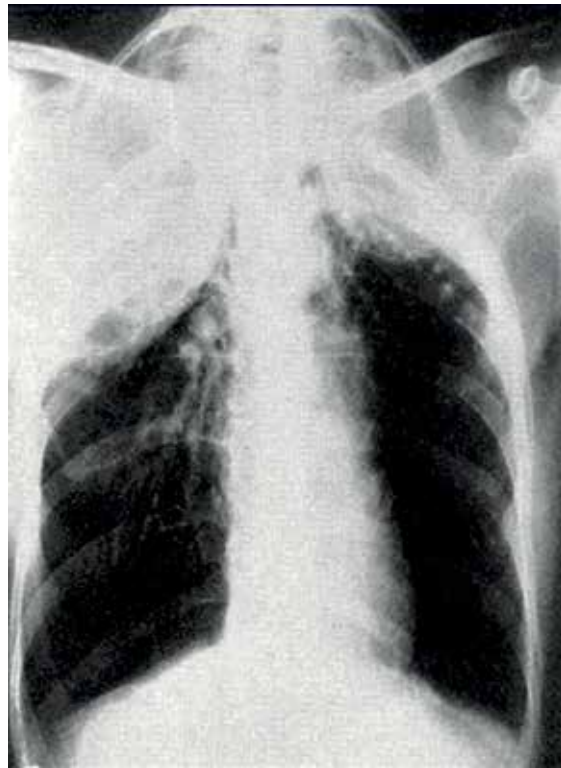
Plumbing X-ray image.
